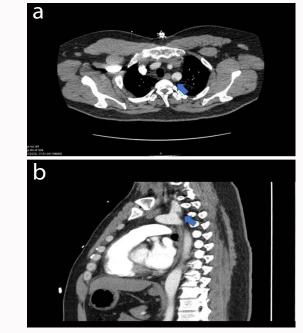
CTA of the chest showing non-occlusive filling defect within the origin of the left subclavian artery.
